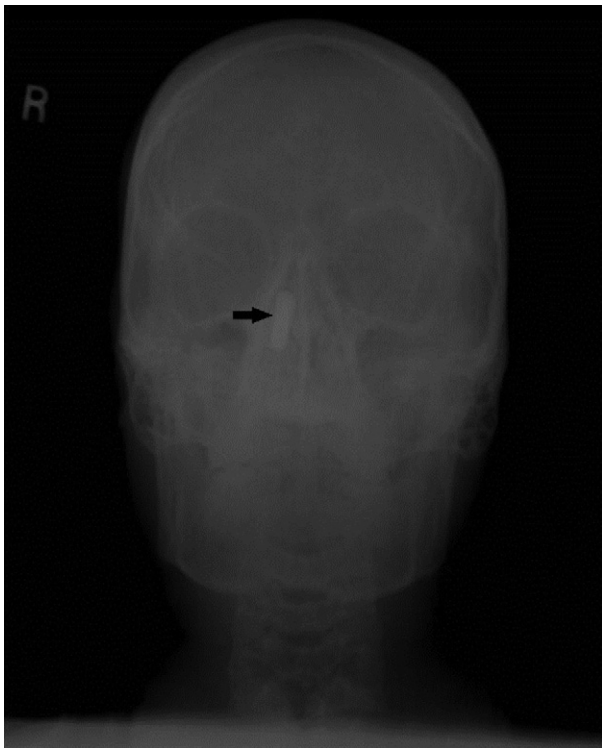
Anterior-posterior view radiograph demonstrating an AK-47 projectile round lodged in the ethmoid sinus.
